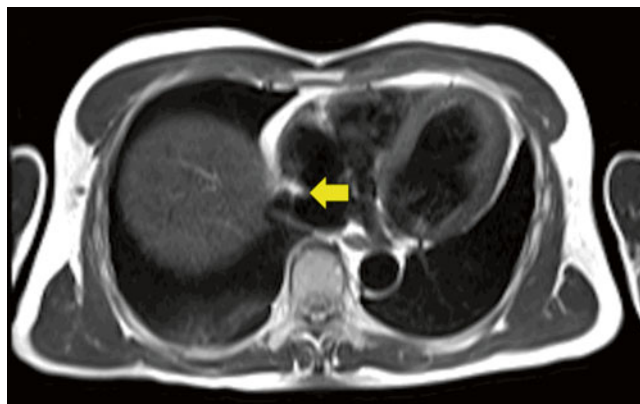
Black blood imaging is shown in a patient referred for cardiac magnetic resonance. A right atrial mass seen by echocardiography corresponded to a prominent Eustachian valve (arrow)
